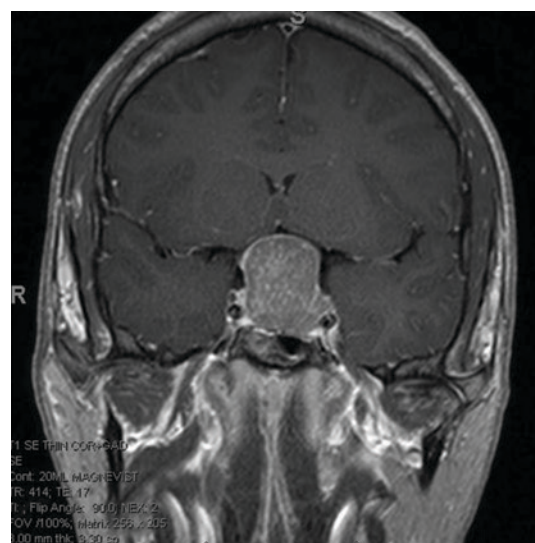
MRI at time of diagnosis.
